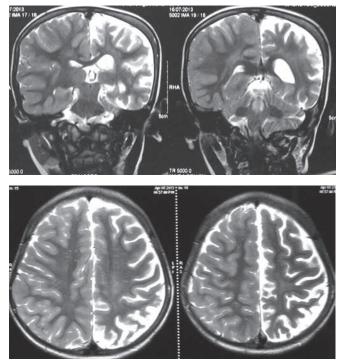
T2 weighted magnetic resonance imaging of brain: left hemispheric atrophy in chronic stage of hemiconvulsion-hemiplegia-epilepsy syndrome
